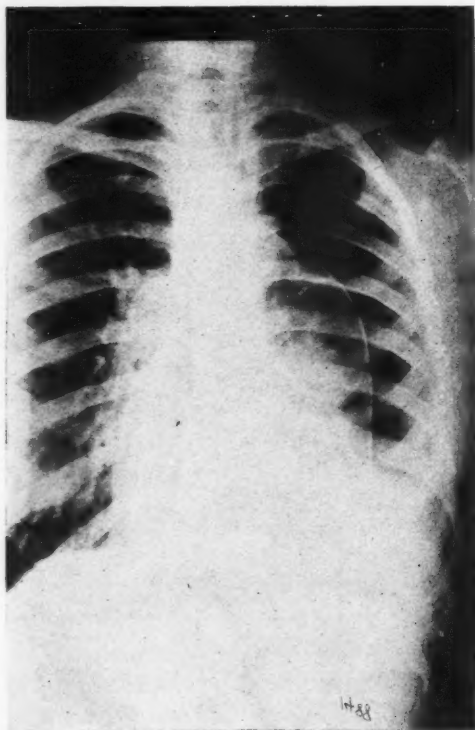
Why the atelectatic lung shows such great density in the X-ray in contrast to the almost transparent structure of lung collapsed to even smaller size from pneumothorax, is difficult to understand and has never been successfully explained. Compare the transparency of lung here shown, collapsed from pneumothorax, with density of atelectatic collapse seen in other radiographs.
